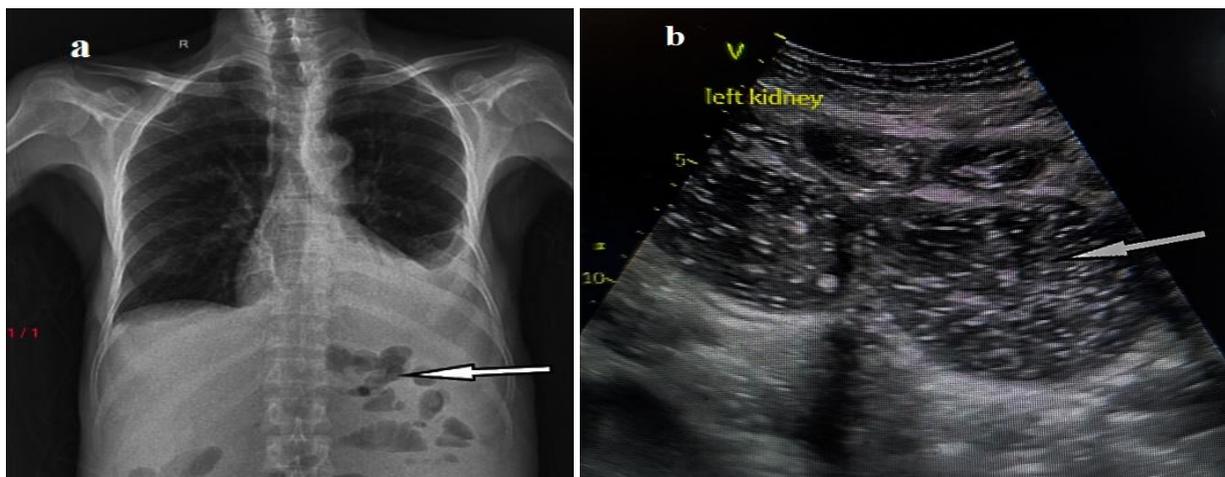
(a) Chest x-ray with abdomen showing left sided pleural effusion with bowel shadows in left renal fossa (white arrow) (b) Ultrasound abdomen showing gross hydronephrosis having internal echoes and causing paper thinning of cortex (white arrow)
